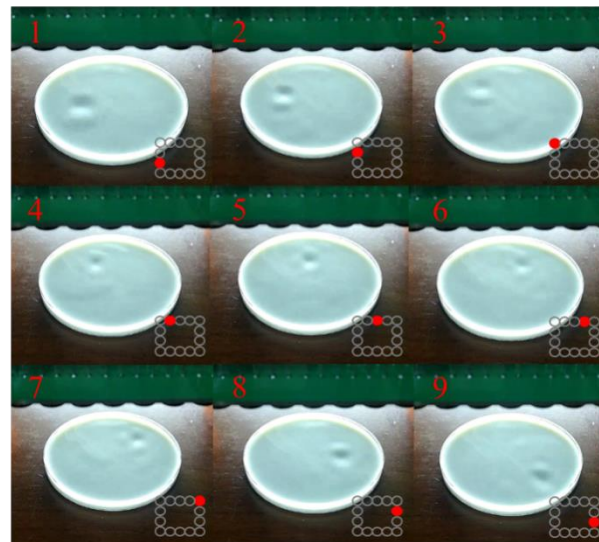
Dynamic movement of the ultrasound focal force.
